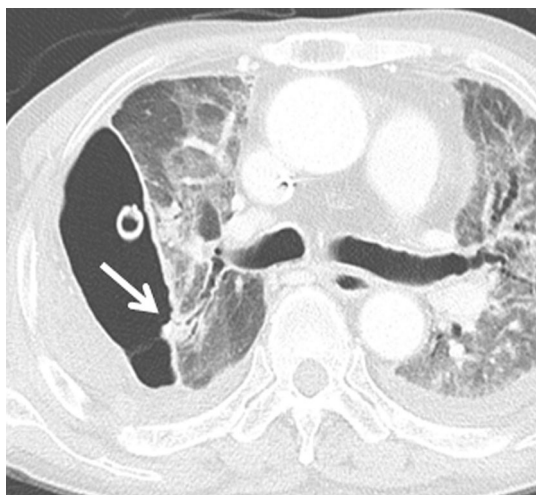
Bronchopleural fistula in a 65-year-old man treated with wedge resection of right upper and lower lobes due to organizing pneumonia. Axial chest CT image shows the communication tract (arrow) between right lower lobe and pleural space. Air and fluid collections in the right pleural space are also noted
